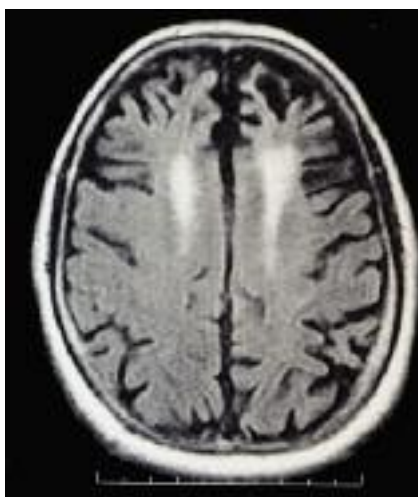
FLAIR MRI showing frontotemporal atrophy with confluent symmetrical high signal intensity change in frontal subcortical white matter.
